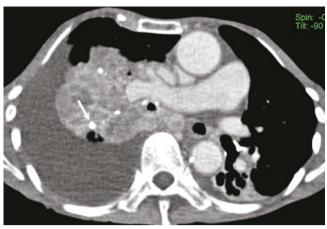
A 74-year-old man with bronchial carcinoma. Contrastenhanced axial CT thorax image shows a right upper lobe mass with few calcified granulomas (arrow). Patient had past history of tuberculosis
